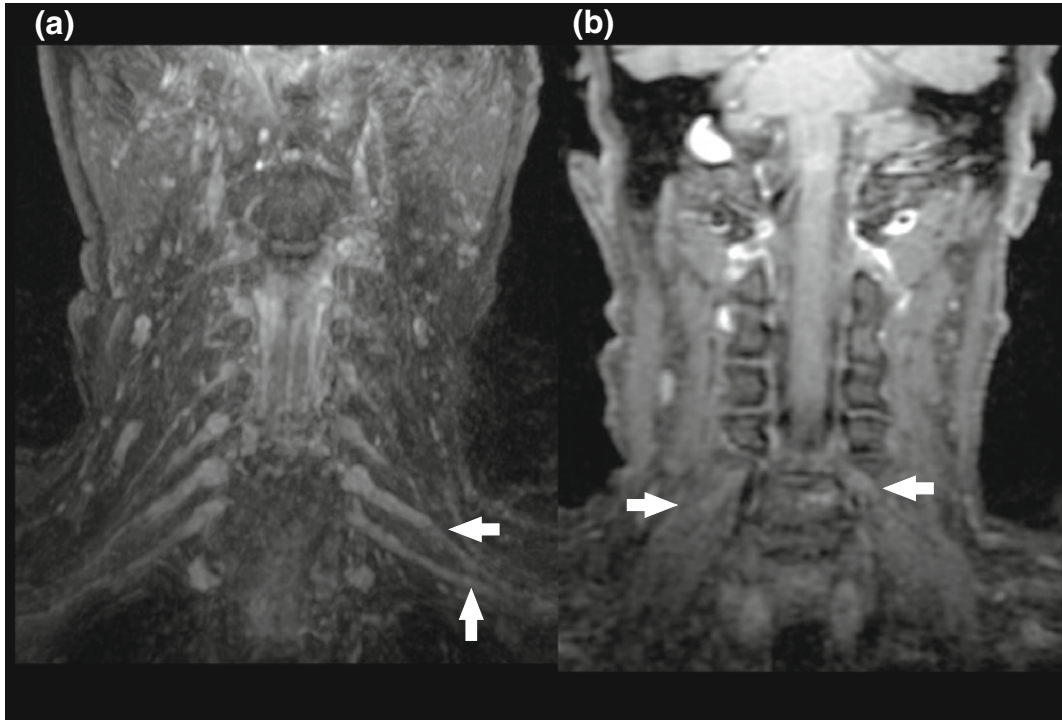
Diabetic neuropathy: brachial MRN in 45 years old man, with uncontrolled diabetes type 2. Sequence 3D IDEAL coronal FAT SAT T2-weighted (a), shows diffusely hypertrophy and hyperintensity signal in both
